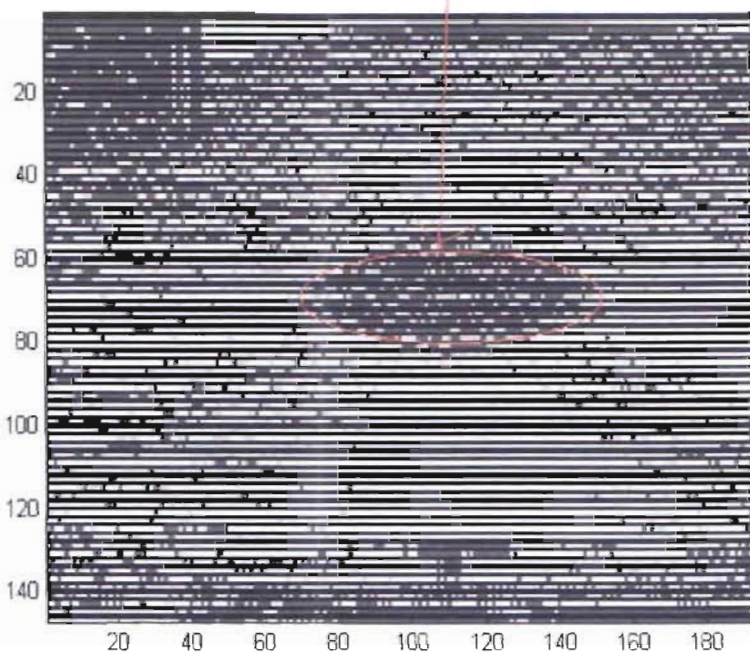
B-mode elasticity image for real ultrasound data using block compression technique.
